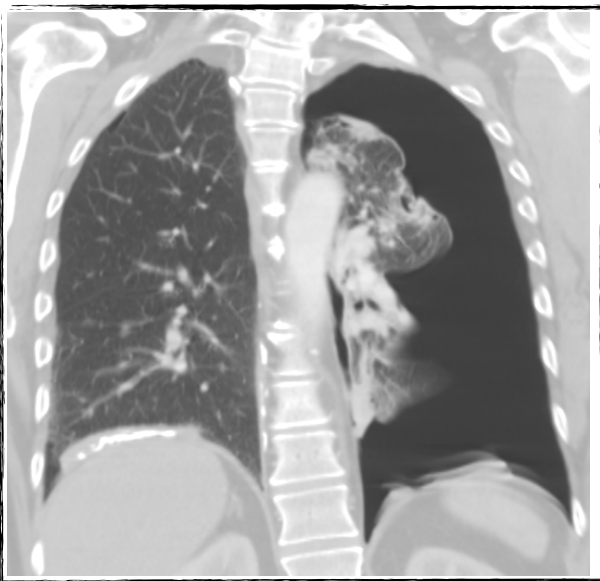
Radiograph of tension pneumothorax with mediastinal shift to left.
